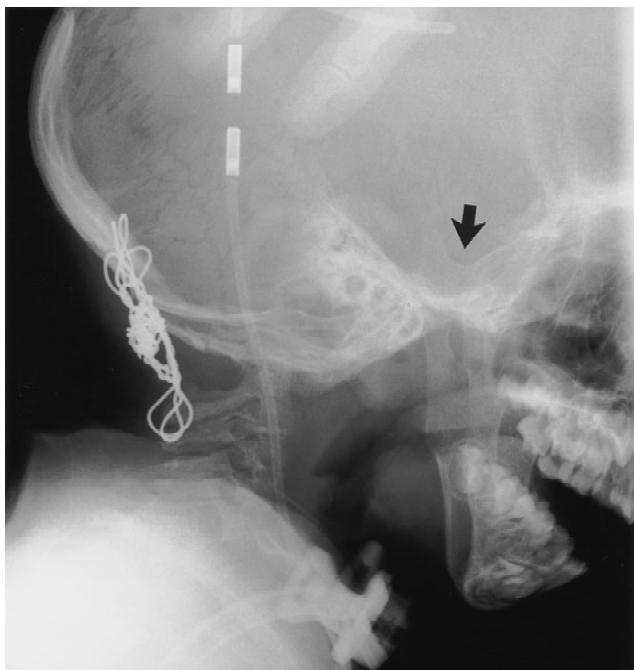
Lateral radiograph of the cervical spine of patient 1, obtained after fusion of the occiput to C2, showing a diminished mandibular angle, a J-shaped sella (arrow) with a not unusually horizontal clivus, and multiple Wormian bones. The bones are mildly osteopenic. C1 is not clearly visualized.
